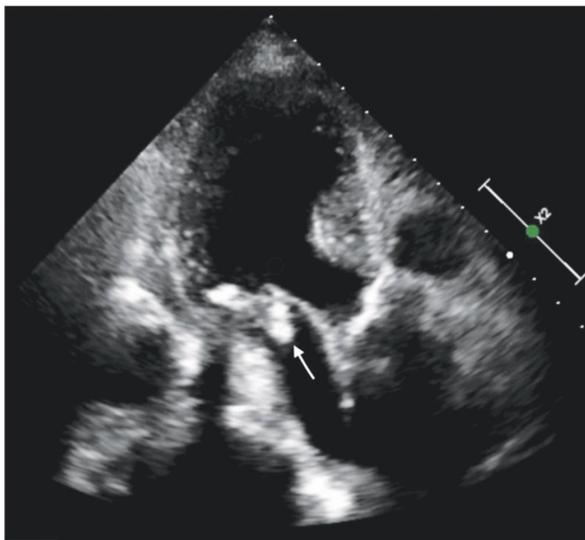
Echocardiographic image of the mitral valve vegetation.
